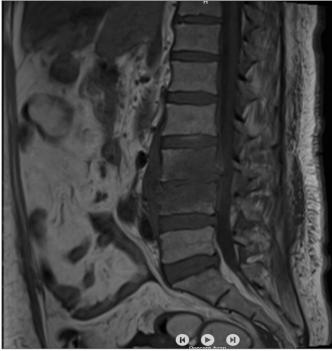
Abscess disc space at L3-L4 on lumbar MRI
